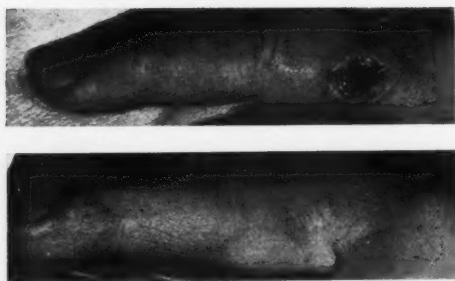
A. G., male, age 54, referred by Dr. Samuel Bennett and Dr. J. V. Klauder, Nov. 21, 1928, on account of an epithelioma, squamous-cell type, affecting the right second finger, of five months' duration, associated with an enlarged lymph node above the right elbow. Destroyed by electrocoagulation, followed by high voltage x-rays covering the diseased channels all the way up to and including the axilla. Well at present over a period of five years.
